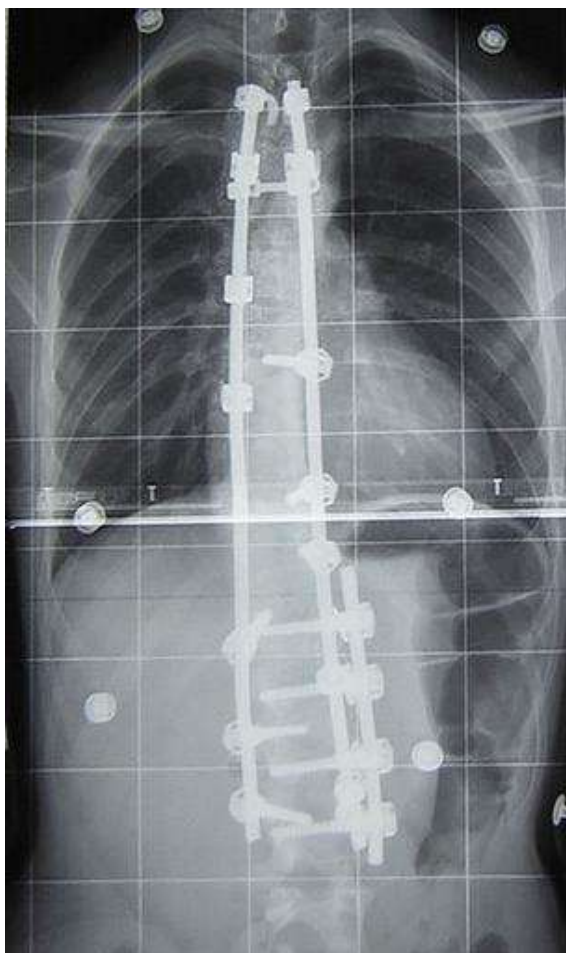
Post-surgical x-ray showing spinal instrumentation straightening an adult spine with scoliosis (Silverjonny 2006) *This image is used under the fair dealing exception.*
